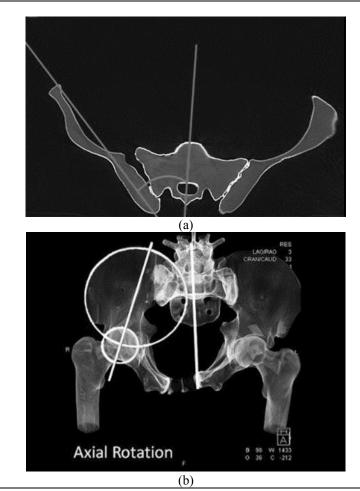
Radiographic measurement of rotational deformity in pelvic fractures: A novel method with validity and reliability testing. (a) The angle between the mid point of the iliac wing and sacrum as a marker of SIJ widening. (b) measuring axial rotation using the angle between a plane created at the midpoint of the spine, and the mid point of the femoral head. Adapted from Nystrom et al. 2015.
